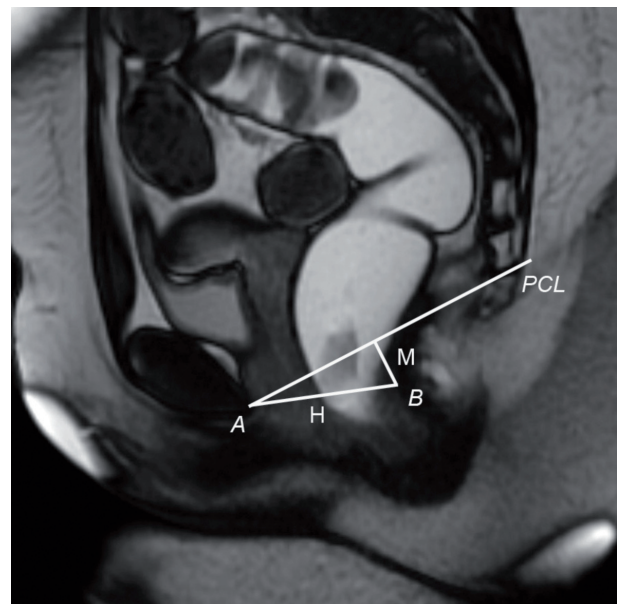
Midsagittal balanced SSFP T2-weighted image, during straining with landmarks used in the HMO system. A-the inferior aspect of the symphysis pubis, B-the posterior wall of the rectum at the level of the ano-rectal junction. The H line (H) represents the anteroposterior hiatal width and extends from A to B. The M line (M) represents hiatal descent and extends perpendicular from the pubococcygeal line (PCL) to the posterior end of the H line.
